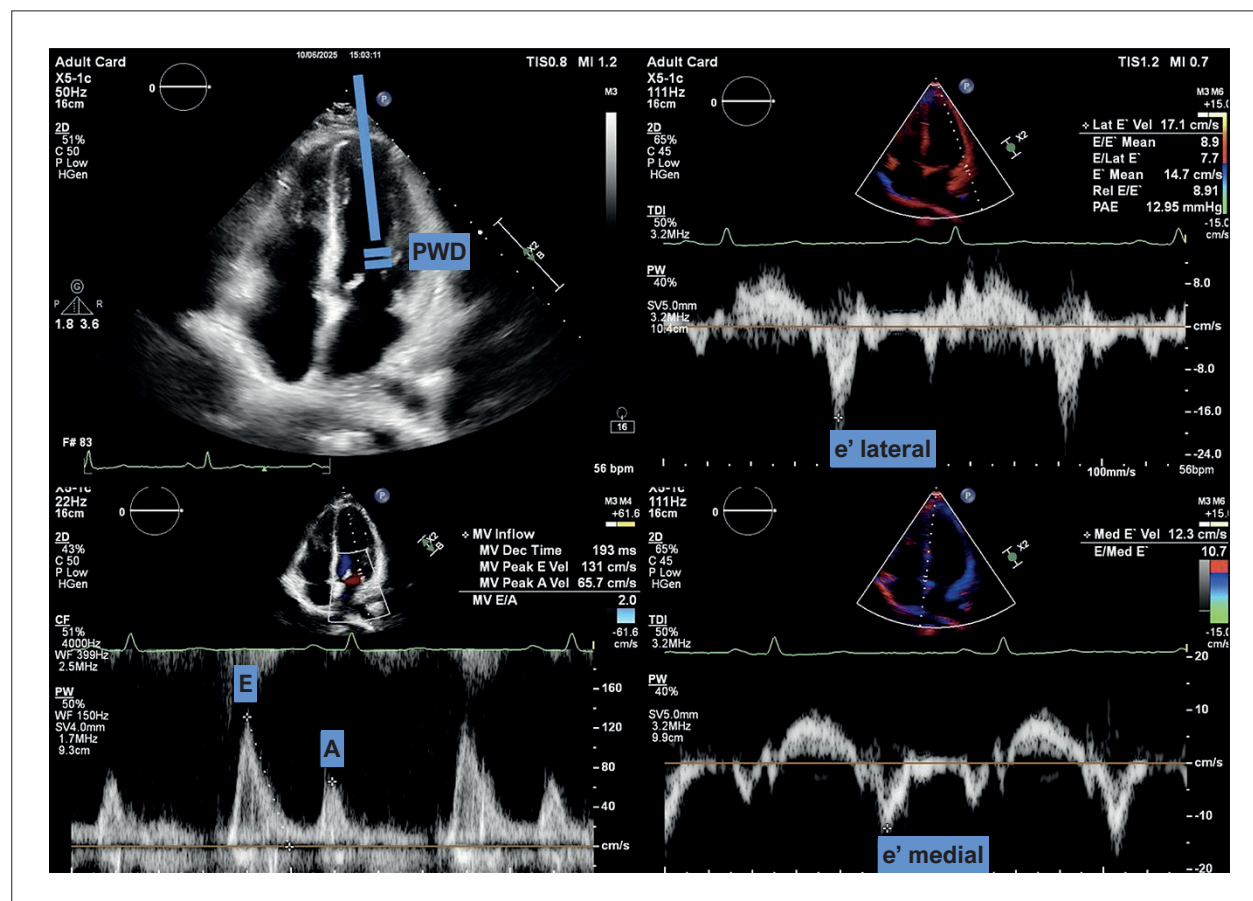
Calculation of the E/e' ratio derived from the relationship between the transmitral E-wave and the average e' wave obtained by tissue PWD imaging at the medial and lateral mitral annulus. PWD: pulsed-wave Doppler.
